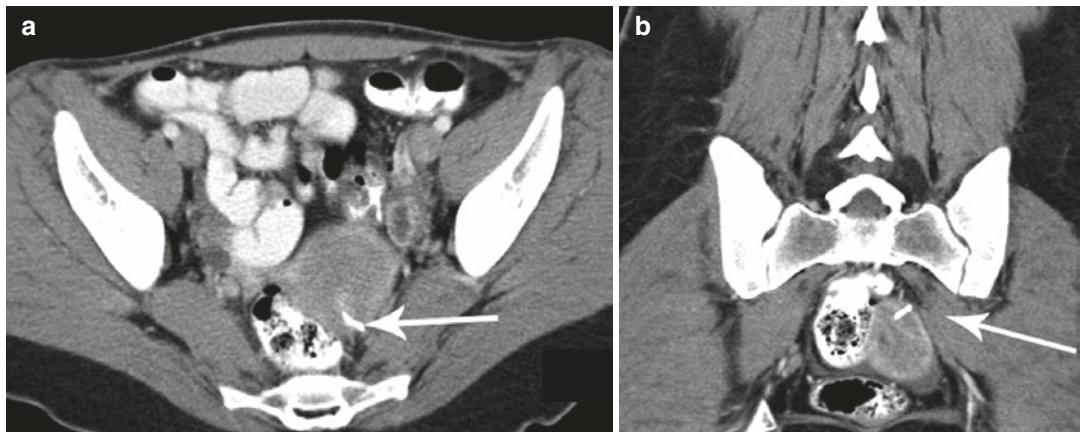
(a) Axial CT image with oral and IV contrast image in a patient with a history of lymphoma perforation of an IUD through the uterine wall (arrow). (b) Coronal CT image of the same patient shows a missed perforated
